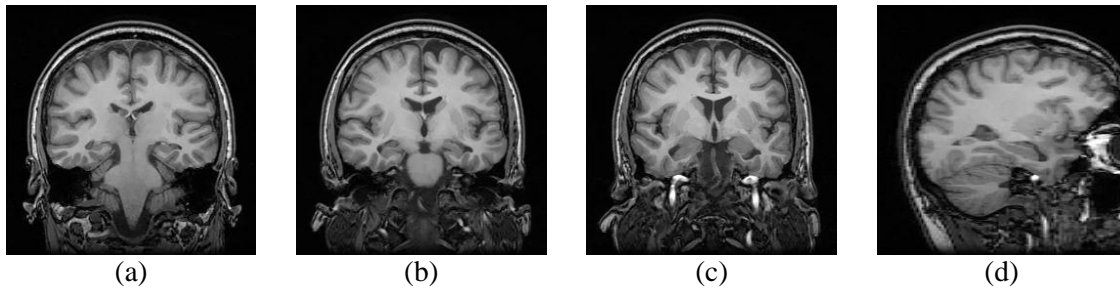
Figures of hippocampus in T1-weighted images of brain MRI. (a)-(c) coronal images from posterior towards the anterior; (d) sagittal view.
